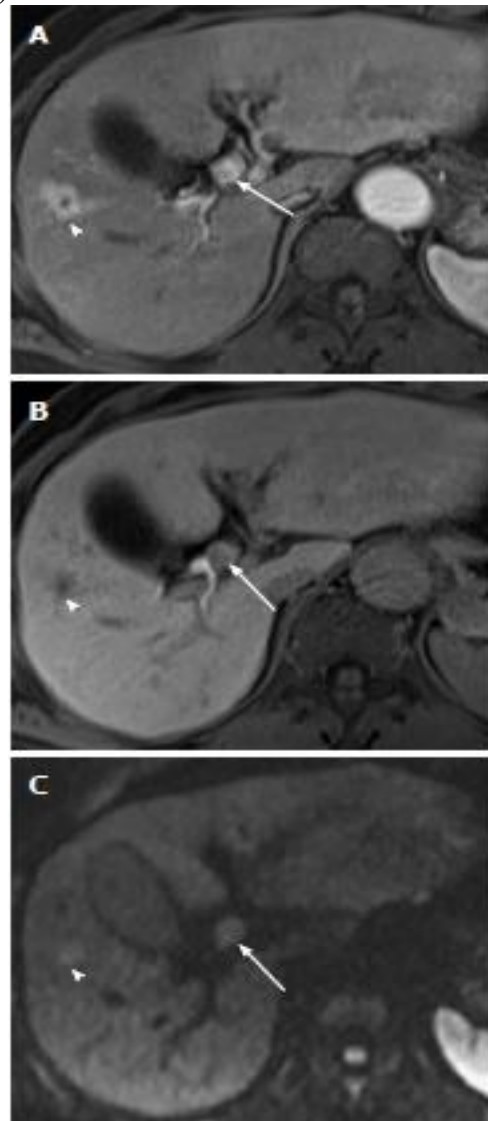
hepatocellular carcinoma with tumor thrombus in bile duct in a 62-year-old man. A: Gadoteric acid-enhanced T1-weighted image obtained during the arterial phase shows a
